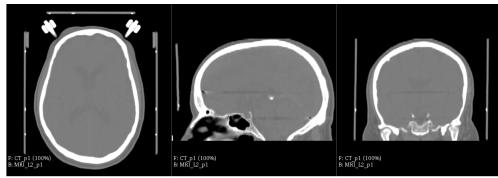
Patient's CT - Target Image.
